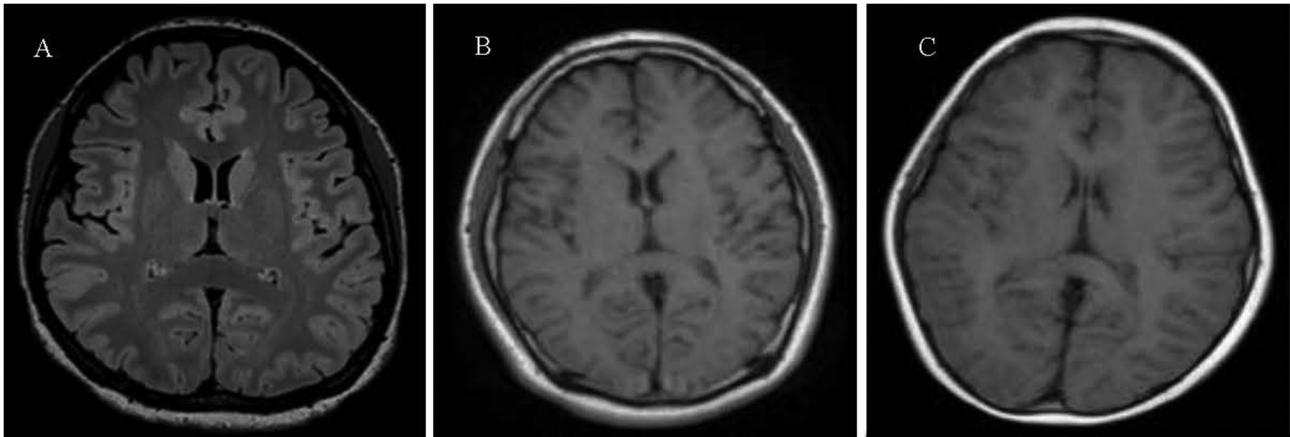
Cranial MRI of the family of the patient. Symmetrical bilateral cerebral hemispheric structures and normal brain white matter contrasts were observed in (A) the mother, (B) father and (C) elder twin sister of the patient, without any abnormal signals.
